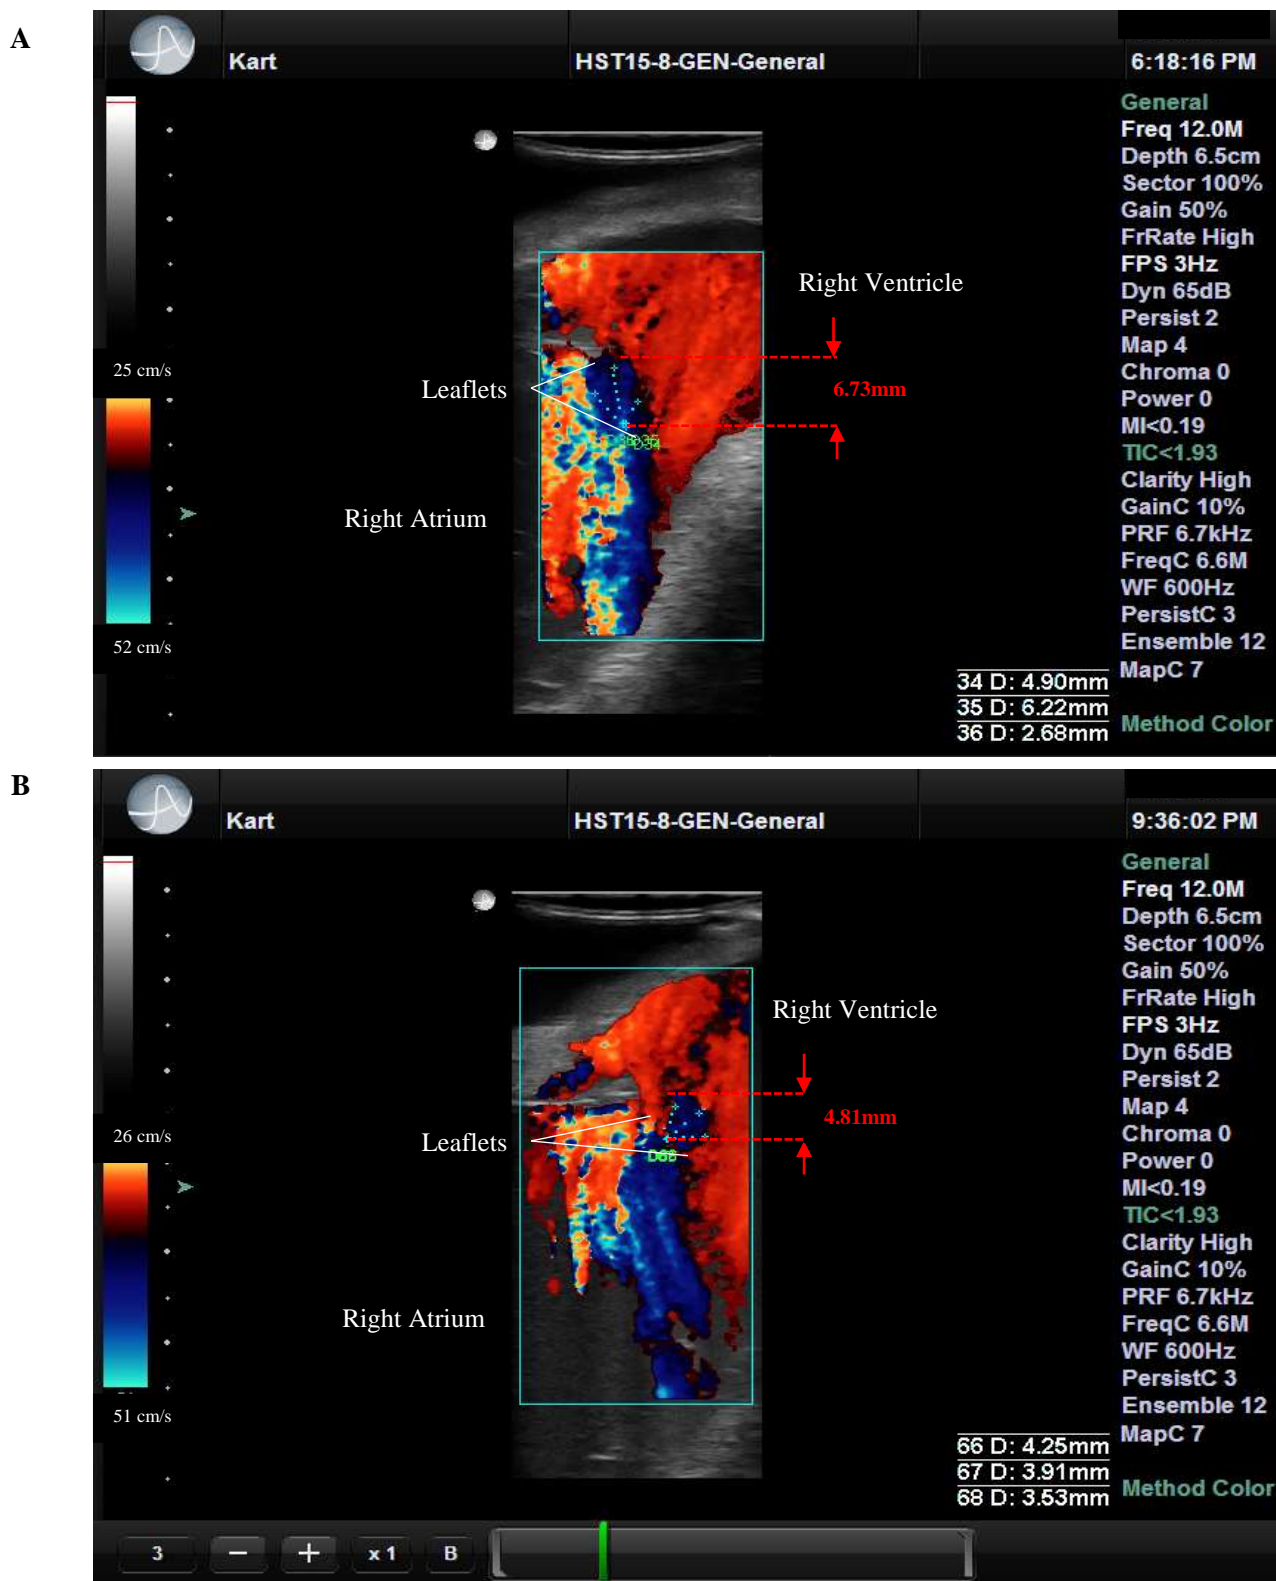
The echocardiographic study to determine the PISAr for (A) Regurgitant model and (B) Ventricularized model.
